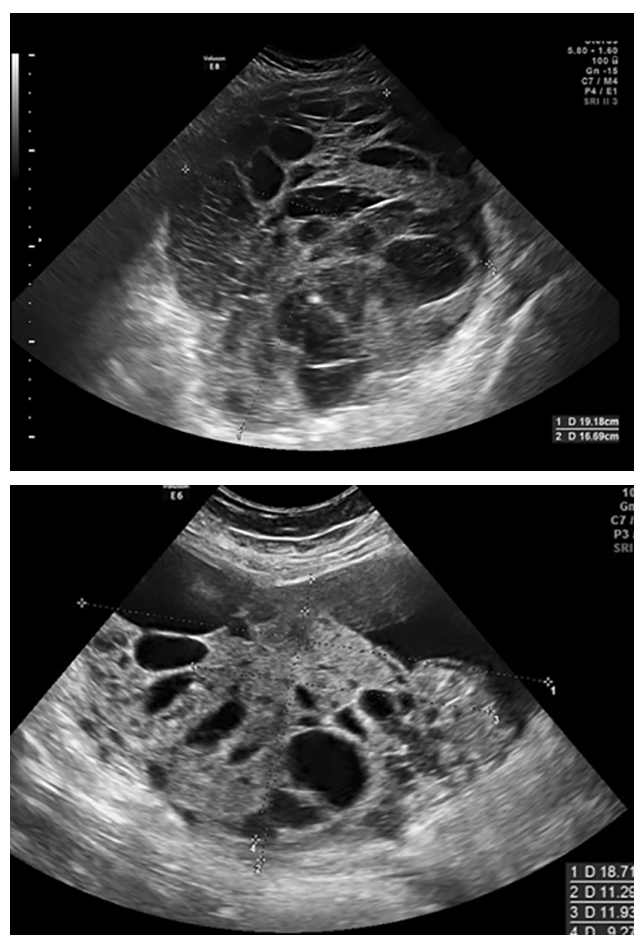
Ultrasound images of two ovarian yolk sac tumors without hyperechoic solid tissue.
